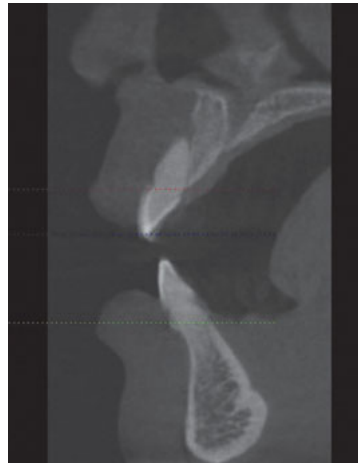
CBCT showing an absence of the buccal bone wall and a periapical lesion at tooth 21.
